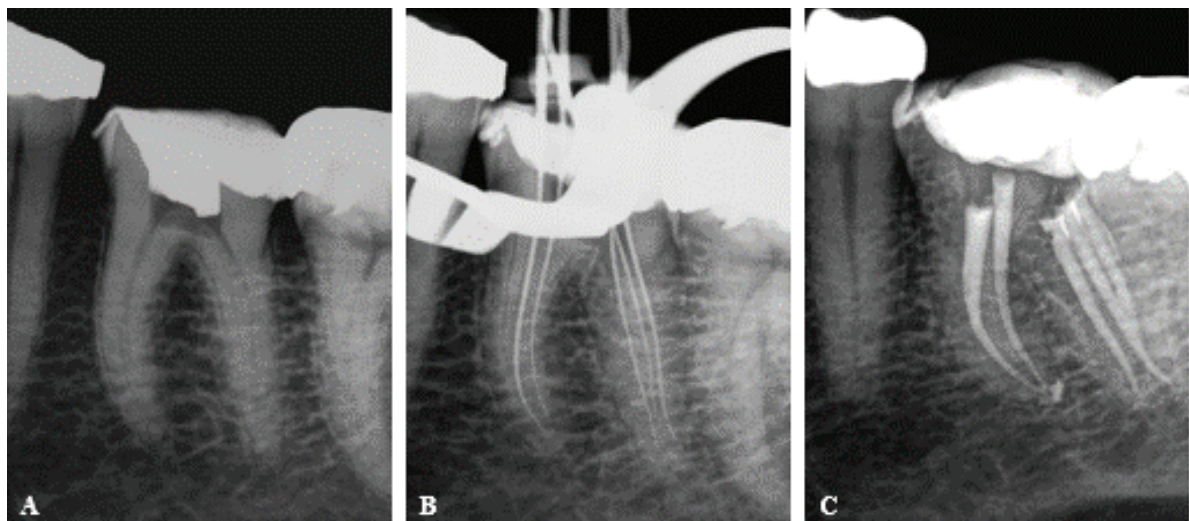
The clinical management of a mandibular first molar with an MD canal; (A) Pre-operative periapical radiograph of a left mandibular first molar; (B) Length determination periapical radiograph. Note the three distal root canal systems in the distal root; (C) Postoperative periapical radiograph after obturation of the five root canal systems. Note that the MD and MB canals join in the apical third of the root while the distolingual canal is separate (3-3-2 configuration in distal root).
